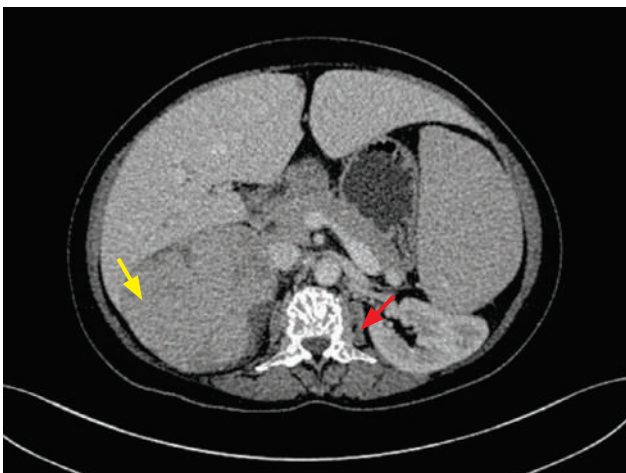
CT scan of the abdomen in 2020 showing size reduction of the right adrenal mass 9.8 x 8.8 x 13.2 cm (yellow arrow) and paraspinal mass (red arrow).
